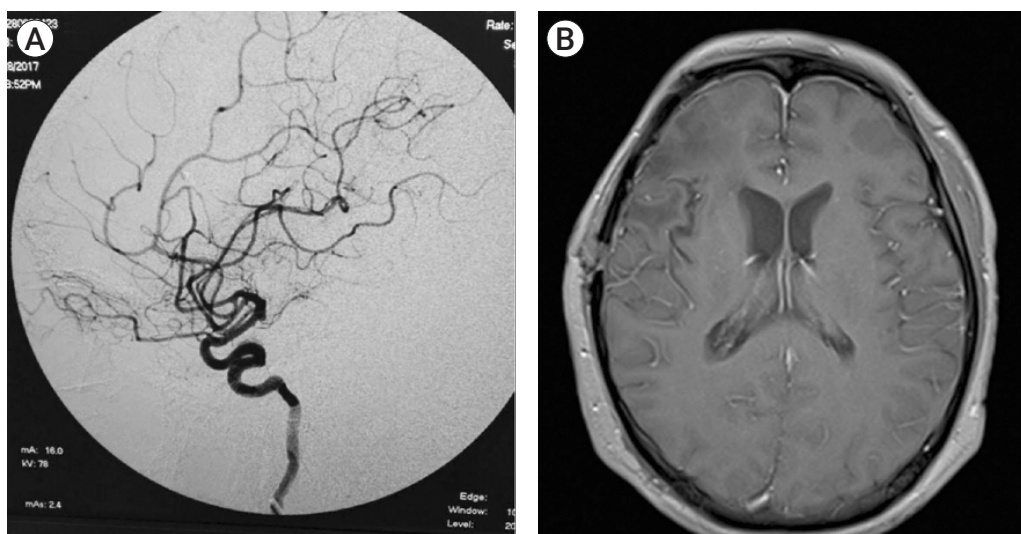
Postoperative cerebral angiography (A) and follow-up MRI (B) confirming the gross total resection of the fronto-temporal granulomatous lesion, as well as of the residual right frontal AVM. MRI, magnetic resonance imaging; AVM, arteriovenous malformation.
